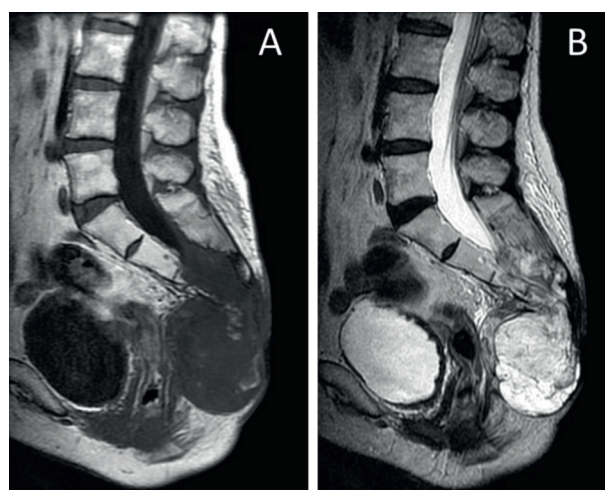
Sagittal magnetic resonance imaging showing that the lesion was homogeneously isointense to skeletal muscle on T1 weighted imaging (A), and heterogeneously hypointense and hyperintense on T2 weighted imaging (B)
